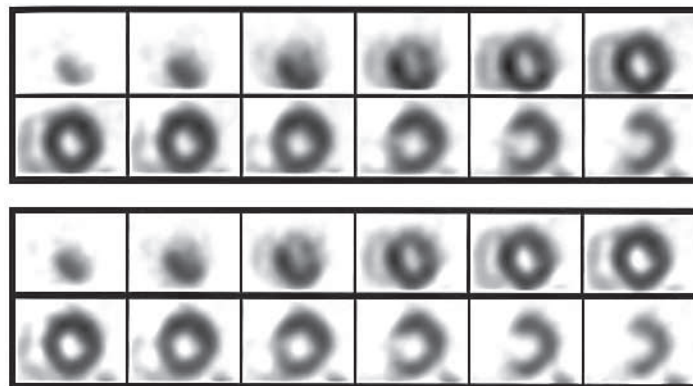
An 86-year-old female with old myocardial infarction in the apical anterior wall (Pt. No. 6). Short-axis SPECT images of ^{99m}Tc-tetrofosmin before (*upper row*) and after (*below row*) the correction. The uptake in the septal-inferior wall before the correction is a little higher than that after the correction.
